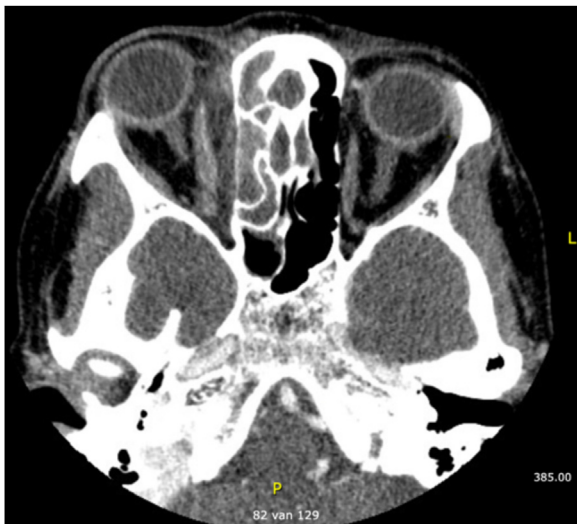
CT scan of the orbital abscess on day 3, showing compression of the medial rectus muscle. Proptosis is present.
